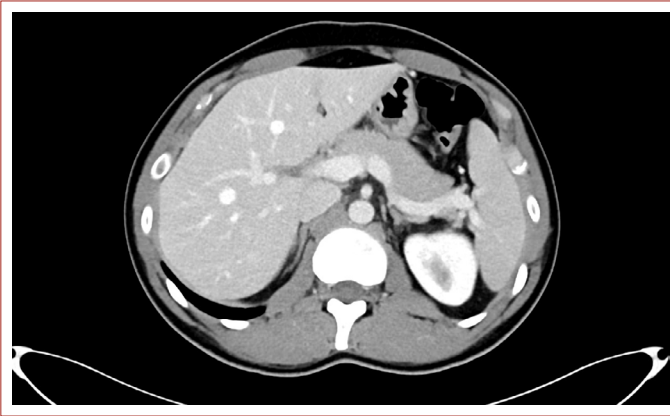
CT image of the donor with no gallbladder.
